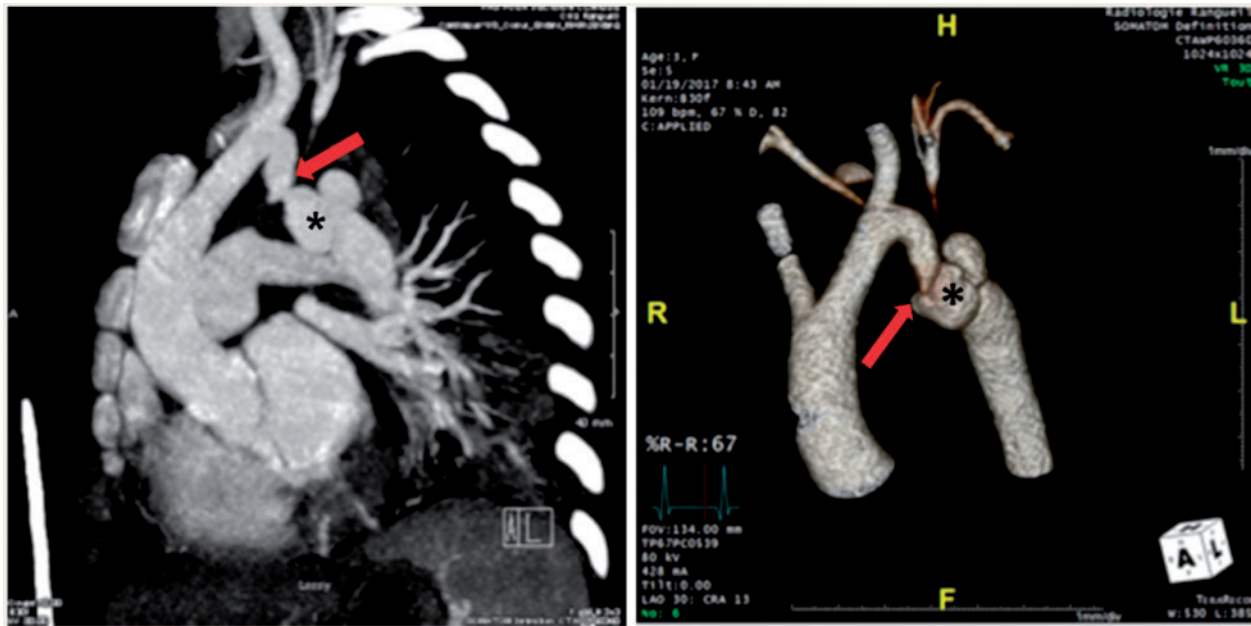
Cardiac computed tomography scan with three-dimensional reconstruction demonstrating coarctation of aorta (arrow) with the pseudoaneurysm (asterisk) below.
